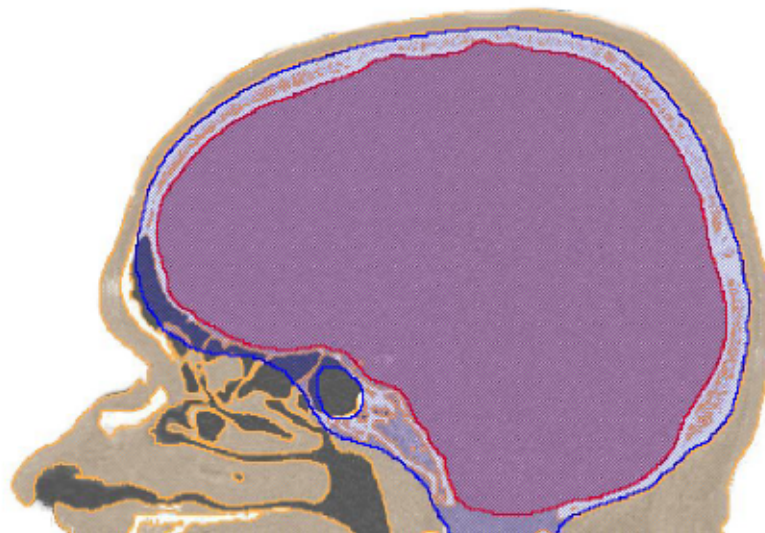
Segmented CT image with labeled intracranial (red), skull (blue) and scalp (orange) compartments.
